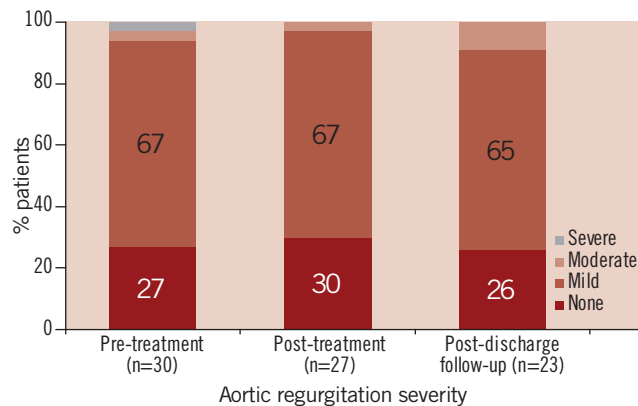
Severity of aortic regurgitation during serial echocardiographic evaluation (n=number of patient echocardiograms with sufficient information for assessment of aortic regurgitation).
